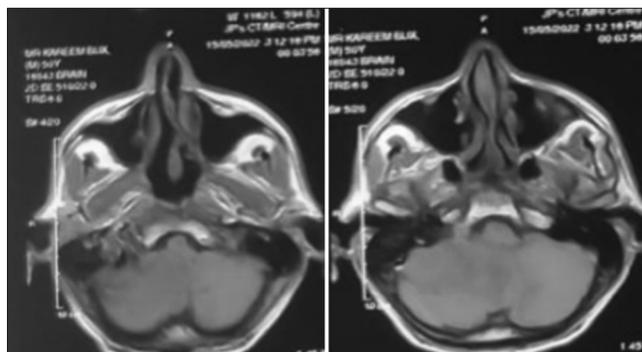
Magnetic resonance imaging brain T1-weighted sequences.
